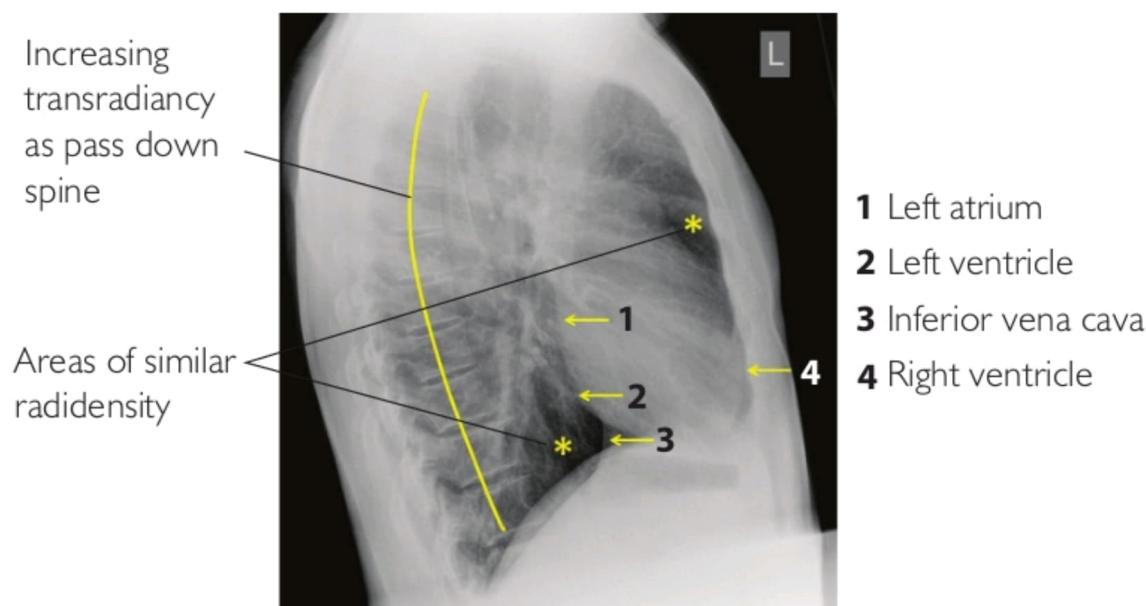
The lateral chest x-ray
